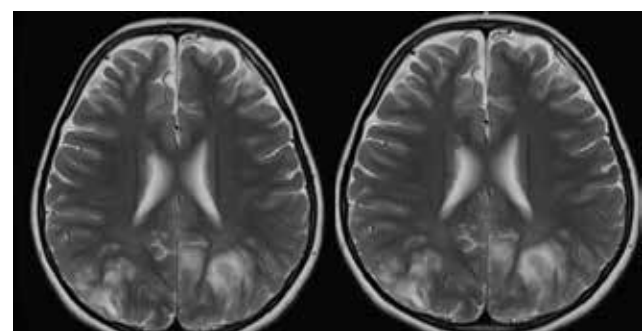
MRI findings of the endocranium of patient 2: posterior reversible encephalopathy with supratentorial cortico-subcortical lesions of the holo-hemispheric type along the “watershed” zones
